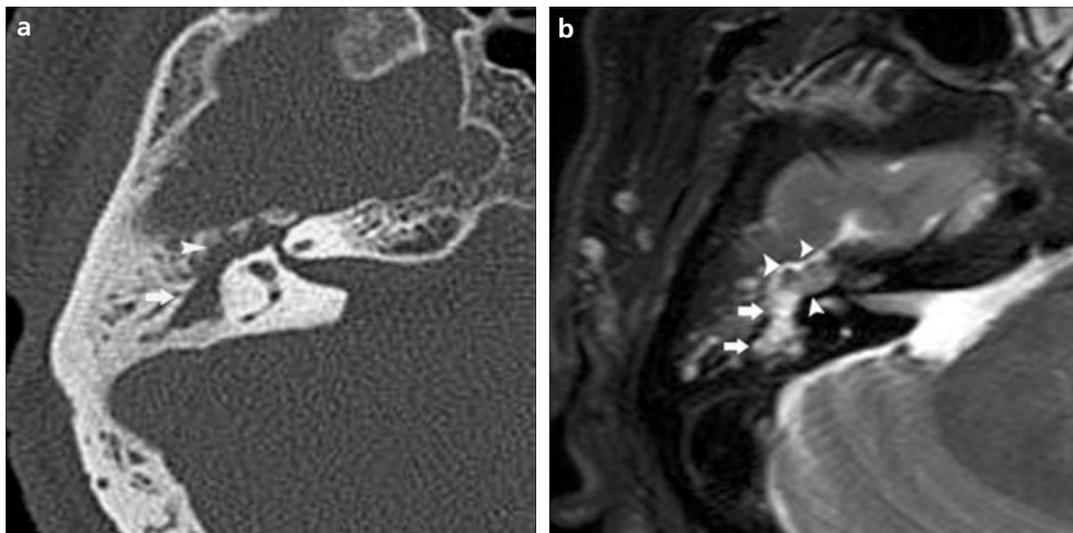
a–c. A true negative HASTE DWI. The axial CT scan shows complete soft tissue opacity in the middle ear and mastoid (*arrow* in the antrum and *arrowhead* in the anterior epitympanum) (a). Axial fat-suppressed T2-weighted MRI shows a high signal in the mastoid antrum, suggesting fluid or granulation tissue (*arrows*), and moderately hyperintense tissue suggestive of a cholesteatoma (*arrowheads*) more anteriorly (b). The coronal HASTE DWI (b-1000) shows no hyperintense lesion indicating the absence of cholesteatoma (*arrowhead*) (c). Dehydrated granulation tissue was verified in follow-up studies.
